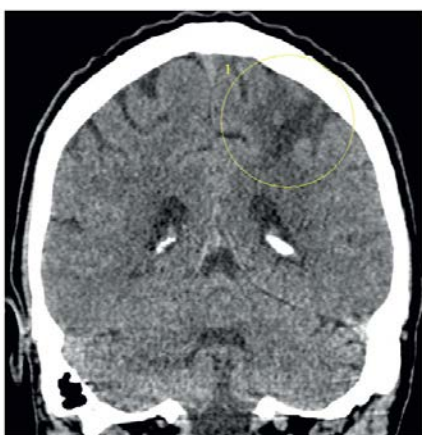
Results of multislice computed tomography of the brain: 1 — area of cistous and gliotic transformation of the left parietal lobe
